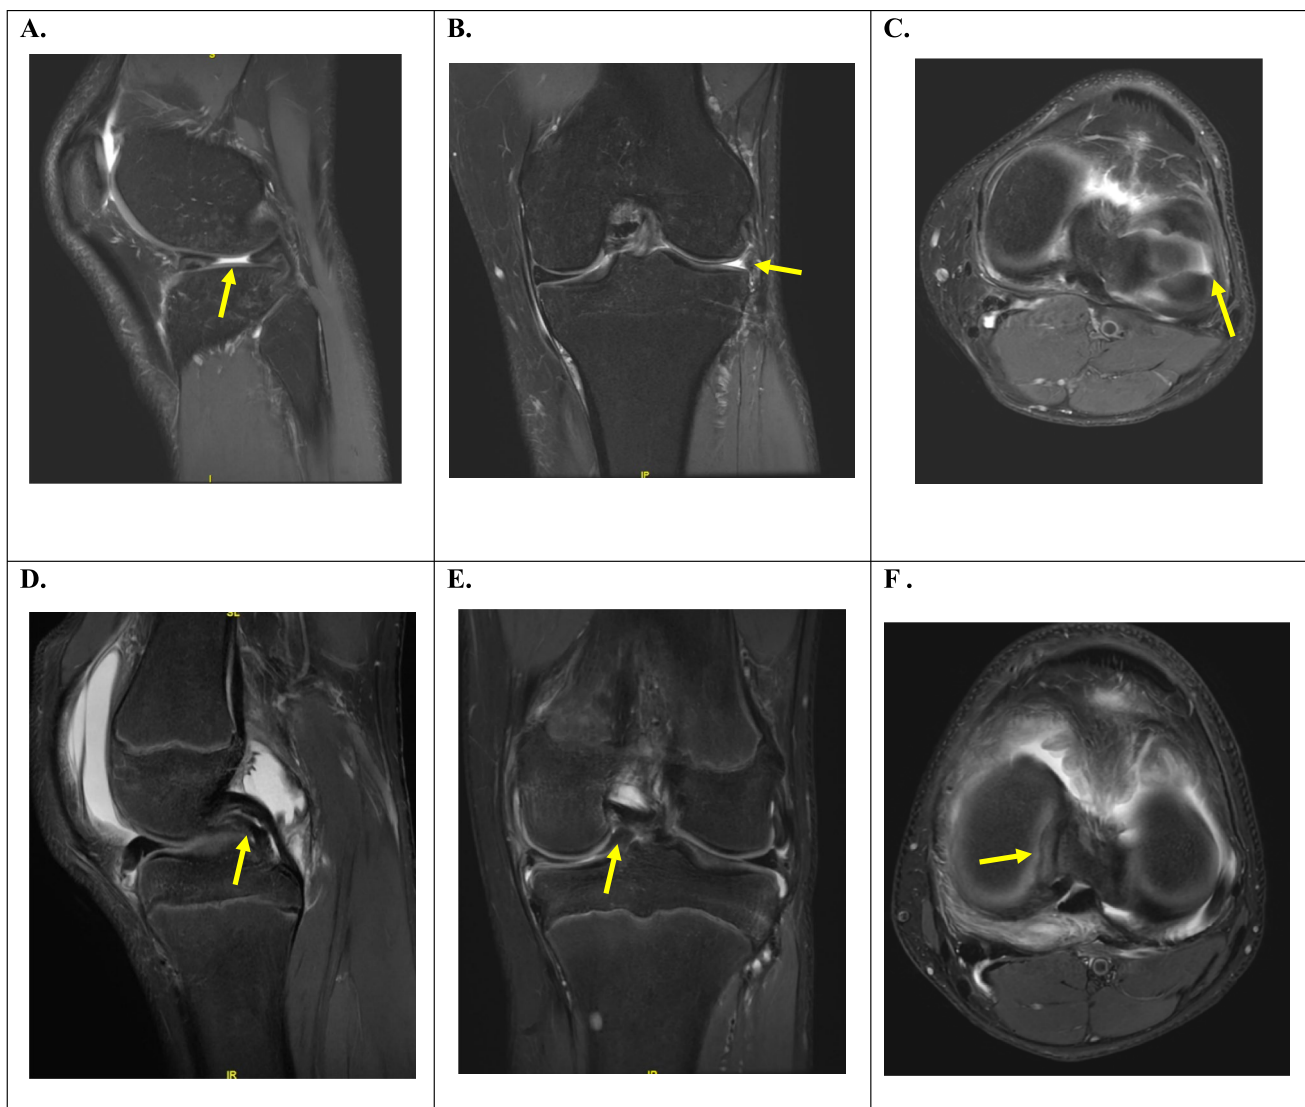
MRI Findings of a Large Lateral Meniscus Radial Tear and a Displaced Medial Meniscus Bucket Handle Tear. STIR MRI sequences demonstrating a large lateral meniscus tear (yellow arrow) in the A Sagittal B Coronal and C Axial sequences. A large medial
